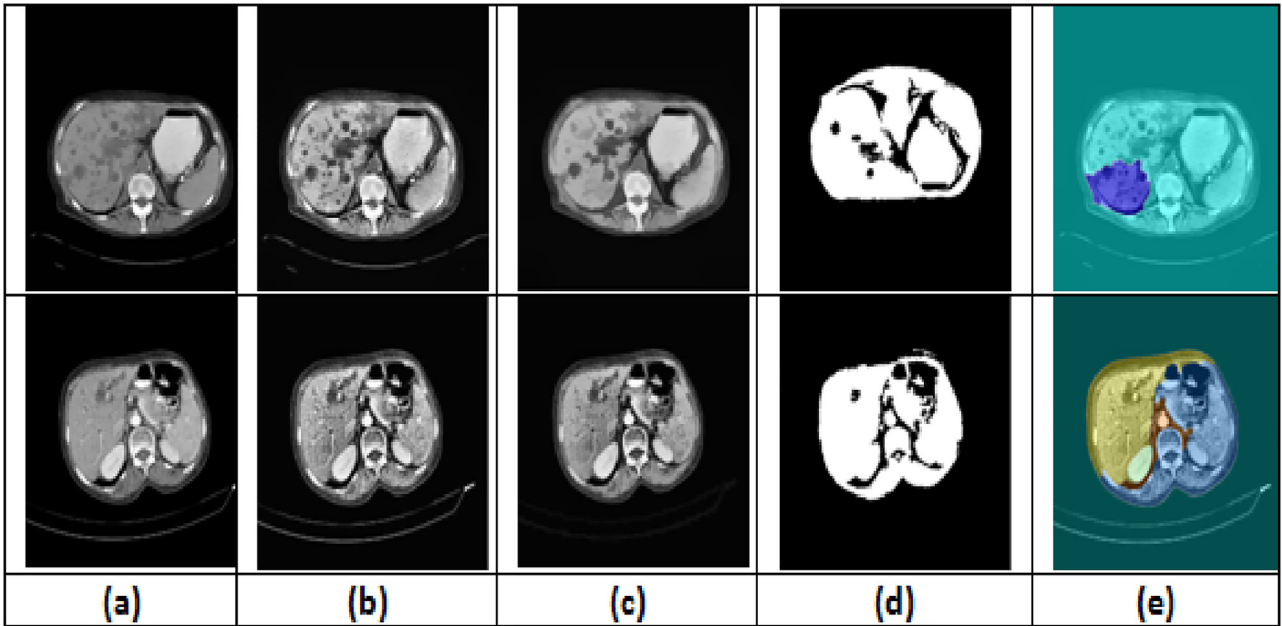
The results of using watershed only. (a) Original CT image, (b) histogram equalization, (c) morphological operators, (d) adaptive thresholding, (e) watershed segmentation.
